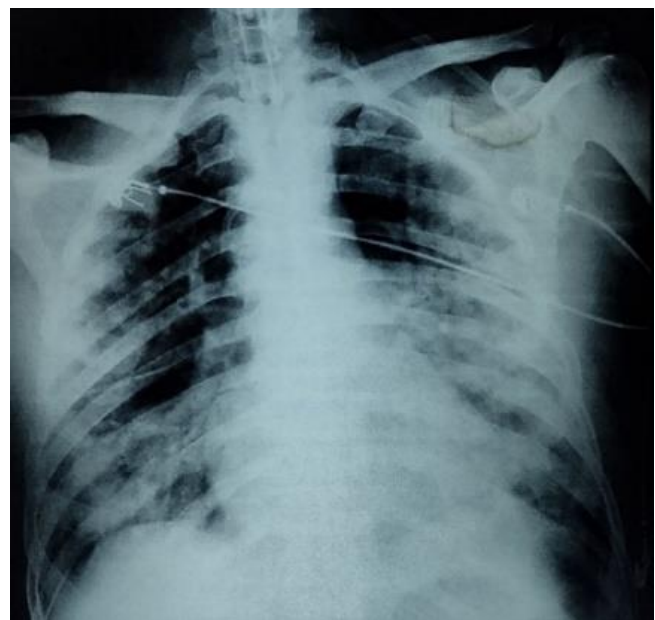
Initial Chest X-Ray Demonstrating Bilateral Pulmonary Infiltrates Indicative of High-Altitude Pulmonary Edema (HAPE).
